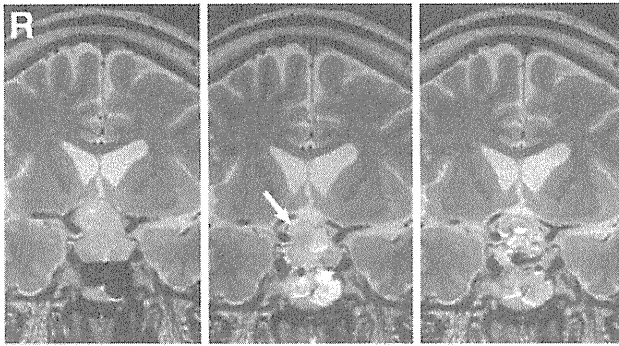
A 51-year-old male with a non-functional pituitary adenoma treated through an endoscopic transnasal approach. Preoperative (left) and intraoperative magnetic resonance (MR) images (middle) revealing a tumor remnant behind the fold of the arachnoid membrane (arrow), which was not visible through the endoscope, and final intraoperative MR image (right) confirming complete resection.
